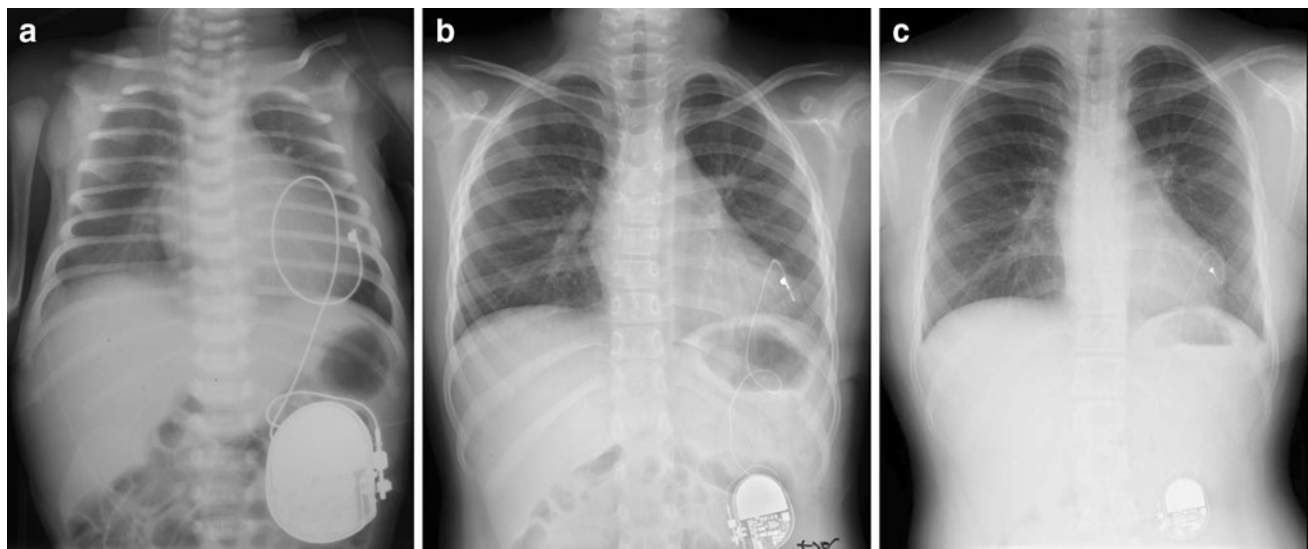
Growth and change in a loop of an epicardial lead. A 16-day-old newborn with congenital atrioventricular block underwent pacemaker implantation using an epicardial lead. Radiographs at
